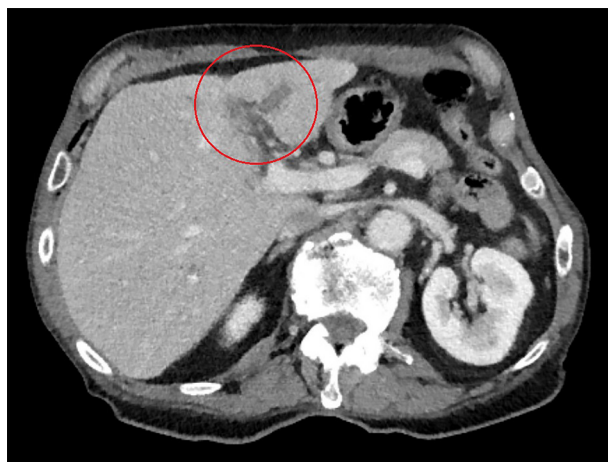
Computed tomography disclosing a thrombosis in the left branch of the portal vein.
